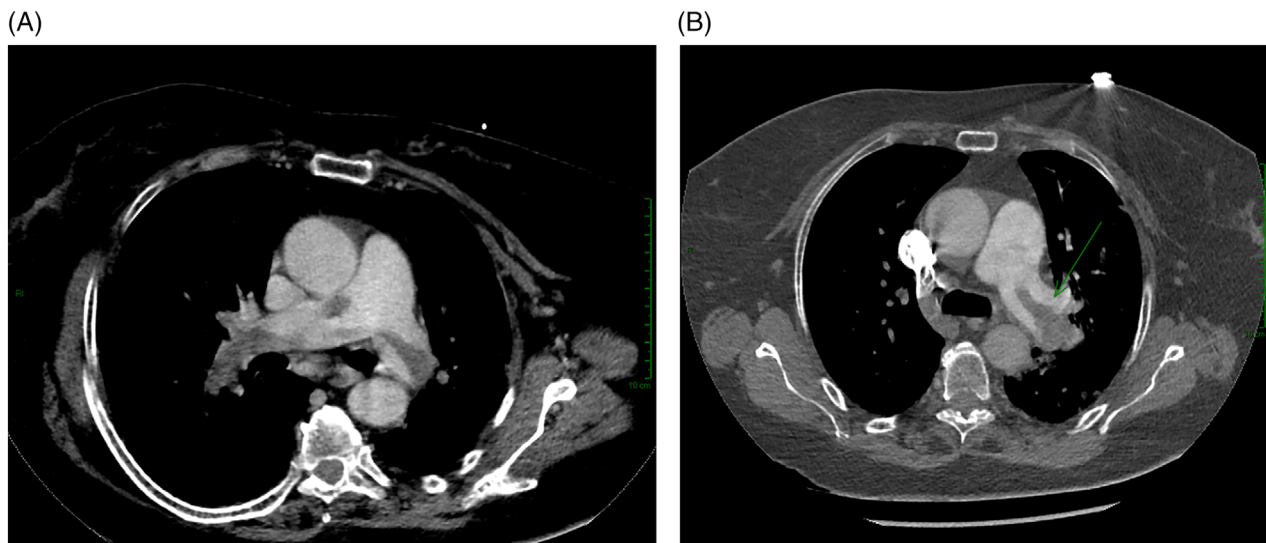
(A) Axial contrast-enhanced computed tomography (CECT) image showing a saddle pulmonary embolism in the right and left pulmonary arteries and seen extending into the right interlobar and segmental arteries. (B) Axial CECT showing a large filling defect in the left main pulmonary artery (indicated by the arrow)
